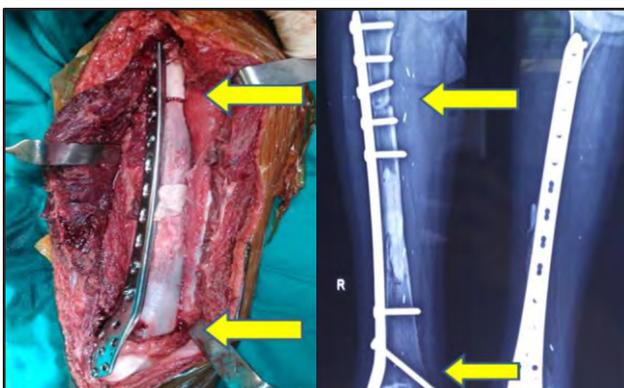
Reimplantation of the irradiated bone and Post implantation MRI scan
